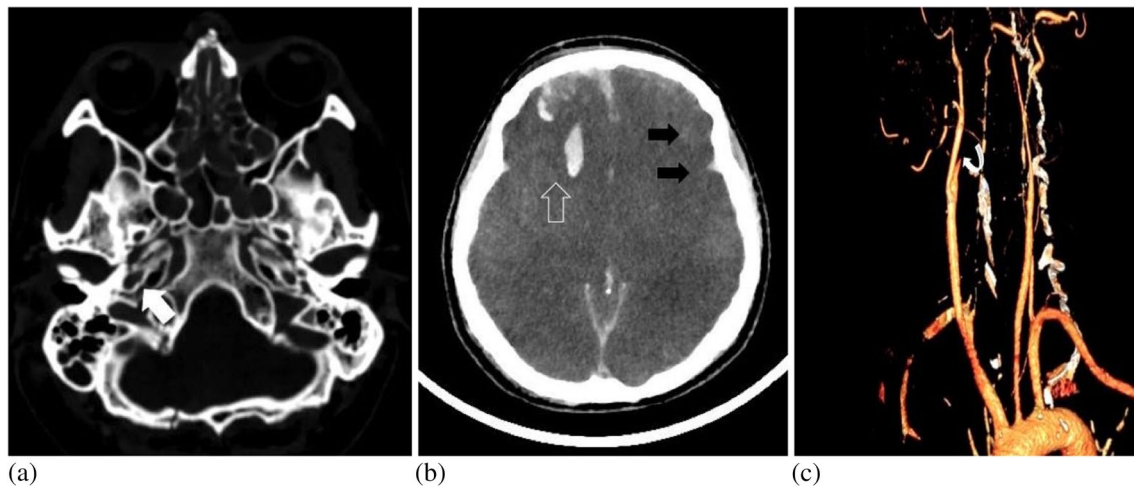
Axial unenhanced CT images of the skull base on bone settings (a) and of the brain (b) and 3D reconstructed CT angiogram of the head and neck (c). There are skull base fractures involving the right carotid canal (solid white arrow) causing occlusion of the right internal carotid artery (ICA) distal to the bifurcation (curved white
